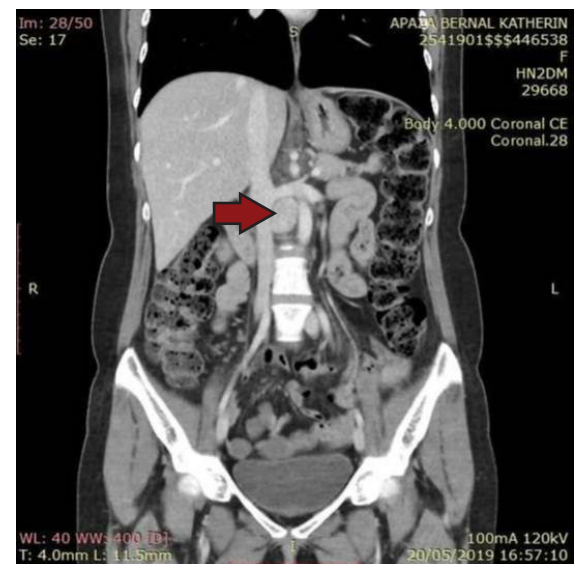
Abdominal CT scan showing intense enhancement after contrast administration, suggestive of a retroperitoneal paraganglioma
